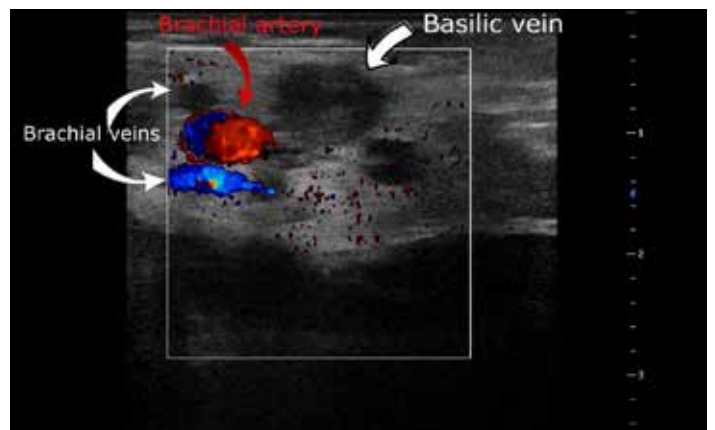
Bedside vascular ultrasound revealed thrombophlebitis at the basilic vein and deep venous thrombosis at the brachial vein. Bedside ultrasound for vascular assessment of upper extremity revealed thrombophlebitis beginning from the cephalic vein and progressing inside the subclavian vein, and beginning at the basilic vein and extending inside the axillary vein, also including the brachial vein.
